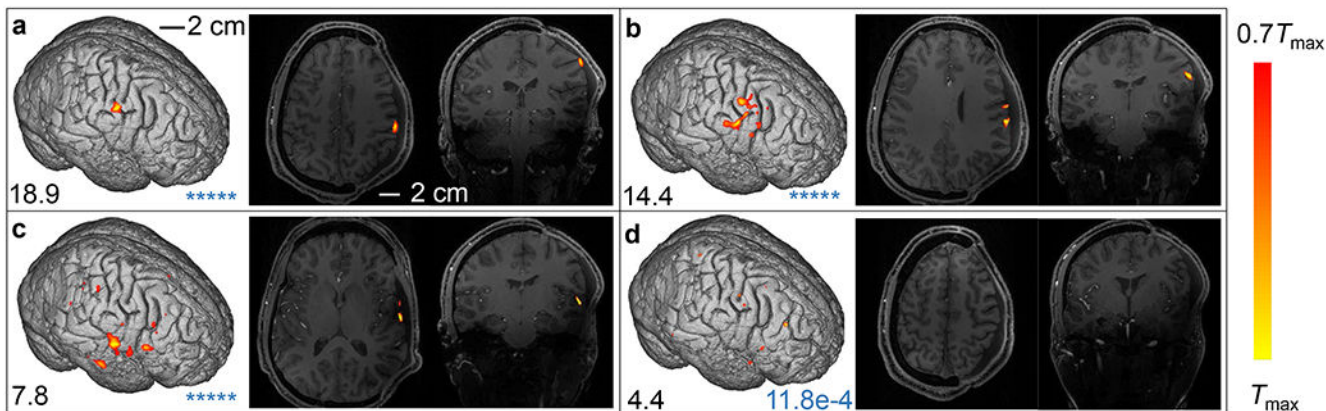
Measuring brain function in a subject who experienced discomfort in MRI due to implants.
